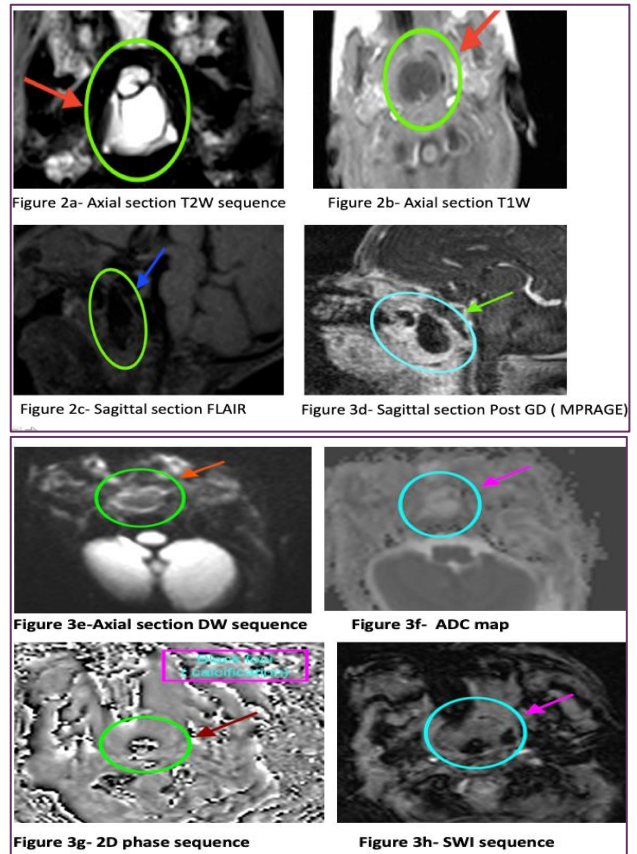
(A-H): Axial T2W sequence shows well defined lobulated hyperintense lesion with thin internal septation. Axial T1W sequence shows hypointense lesion. Axial flair sequence shows suppression. Sagittal MPRAGE sequene the lesion shows thick peripheral enhancement and enhancing thin internal septation. DWI and ADC sequence- no restriction seen. 2D phase sequence shows few bright and dark signal (soft calcification) within the lesion. SWI sequence shows few dark areas within s/o bleed.
